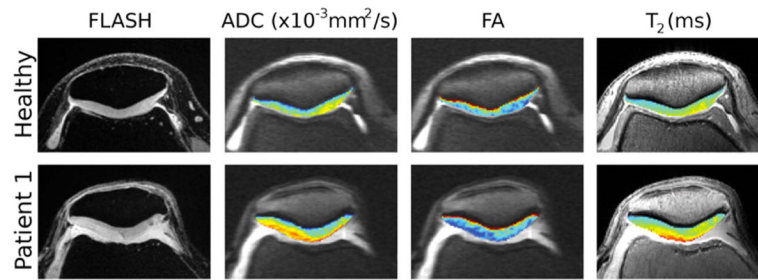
High-spatial-resolution morphologic MR images and MR imaging parameter maps (ADC, FA, and T₂) in healthy volunteer (top row: 31-year-old man, right knee) and a subject with OA (bottom row: 60-year-old woman, Kellgren-Lawrence grade of 3) (Figure reprint from reference (79), with permission).
